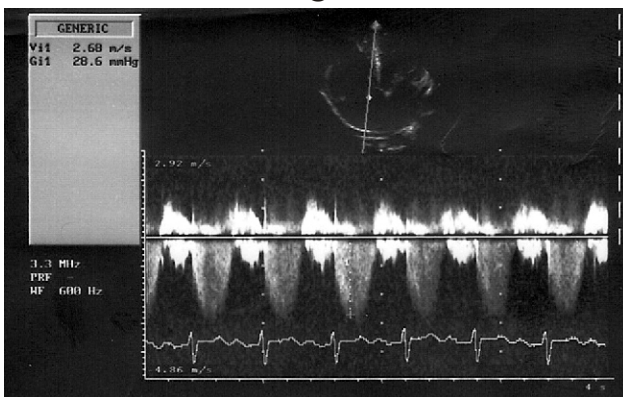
(A, B, C) is a continuous wave Doppler from a 10 year old patient showing regurgitations across mitral, aortic and tricuspid valves respectively with estimated pulmonary pressure of 38.6 mmHg. All the four cardiac valves were affected.
